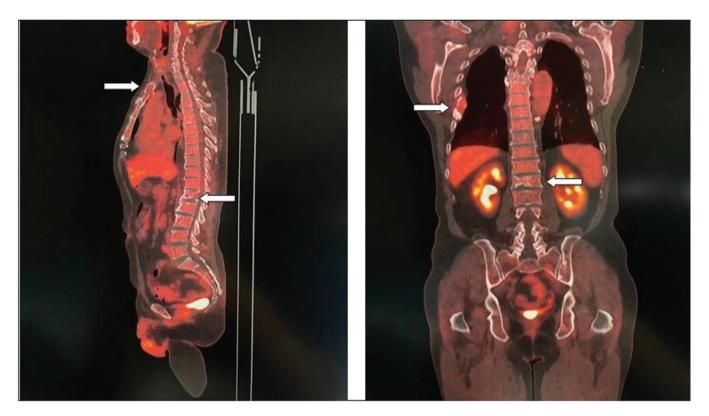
Positron emission tomography/computed tomography examination after 1 year of diagnosis of multiple myeloma. The upper sternum, right seventh rib and first lumbar spine still have obvious lesions (arrows).
